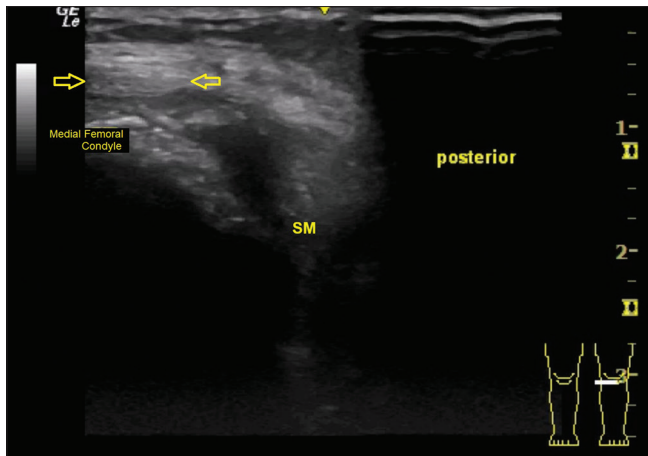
Transverse ultrasound of the left gracilis tendon anterior to medial condyle – Case 2, a 72-year-old female with prior left total knee arthroplasty and painful snapping of the medial knee. The gracilis tendon is imaged in short axis knee extension after snapping over the medial femoral condyle. The gracilis is still seen as hyperechoic, but now more flattened after snapping. Arrows denote the gracilis tendon, SM – semimembranosus tendon. The dynamic ultrasound is demonstrated in Supplemental Video 4.
